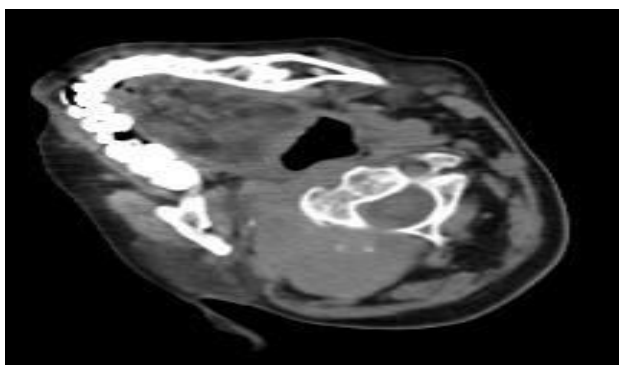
MRI Brain: Bony metastatic expansile lesion involving right occipital condyle & C1 body.
